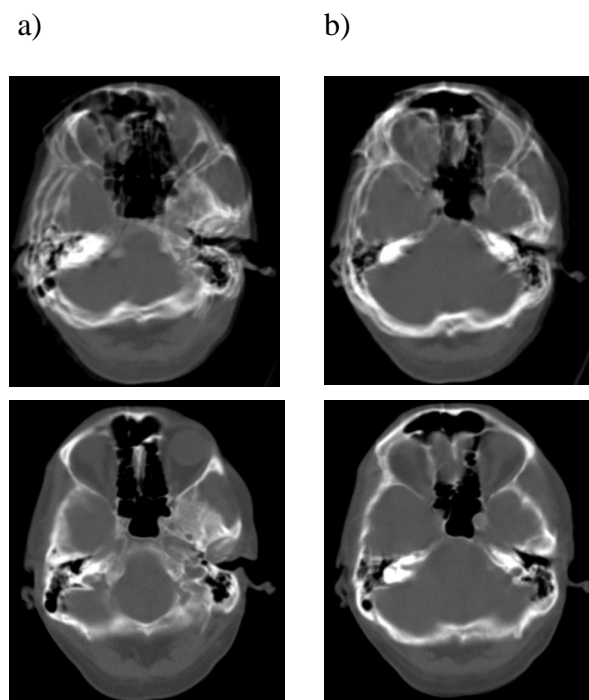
A 58-year-old man's head CT scan, two different CT scan slices are shown, (a-b) the top row is original scan slices with motion, bottom row is motion-corrected.
